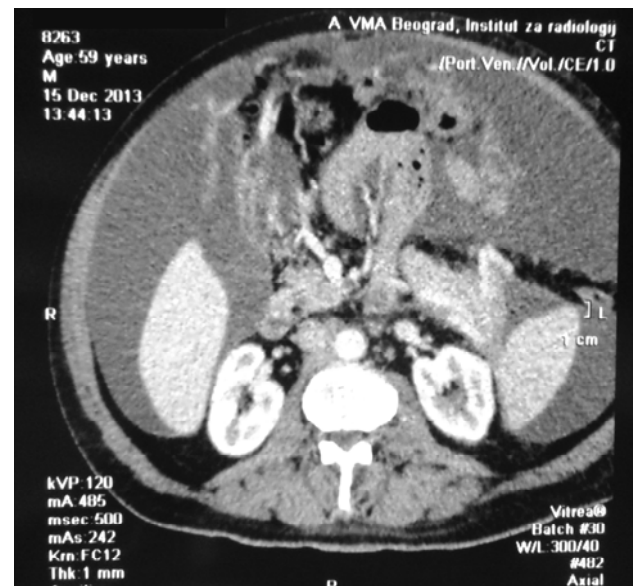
Multislice computed tomography of the abdomen revealed ascites in a patient with non-Hodgkin lymphoma.
